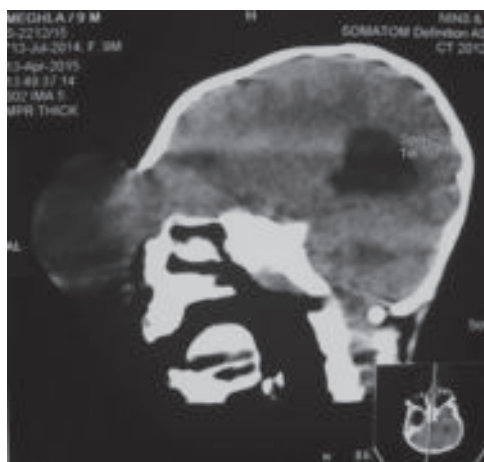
CT scan head showing bony defect
